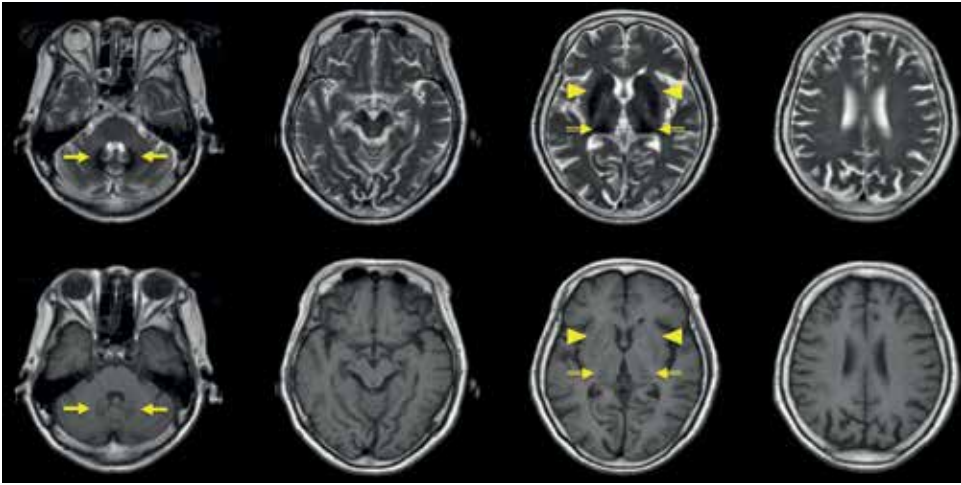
The brain MRI findings in a patient with aceruloplasminemia. T1-weighted (lower row) and T2-weighted (upper row) axial images of the brain showed signal attenuation of the dentate nucleus of the cerebellum (arrows), basal ganglia (arrowheads), and thalami (double arrows).
